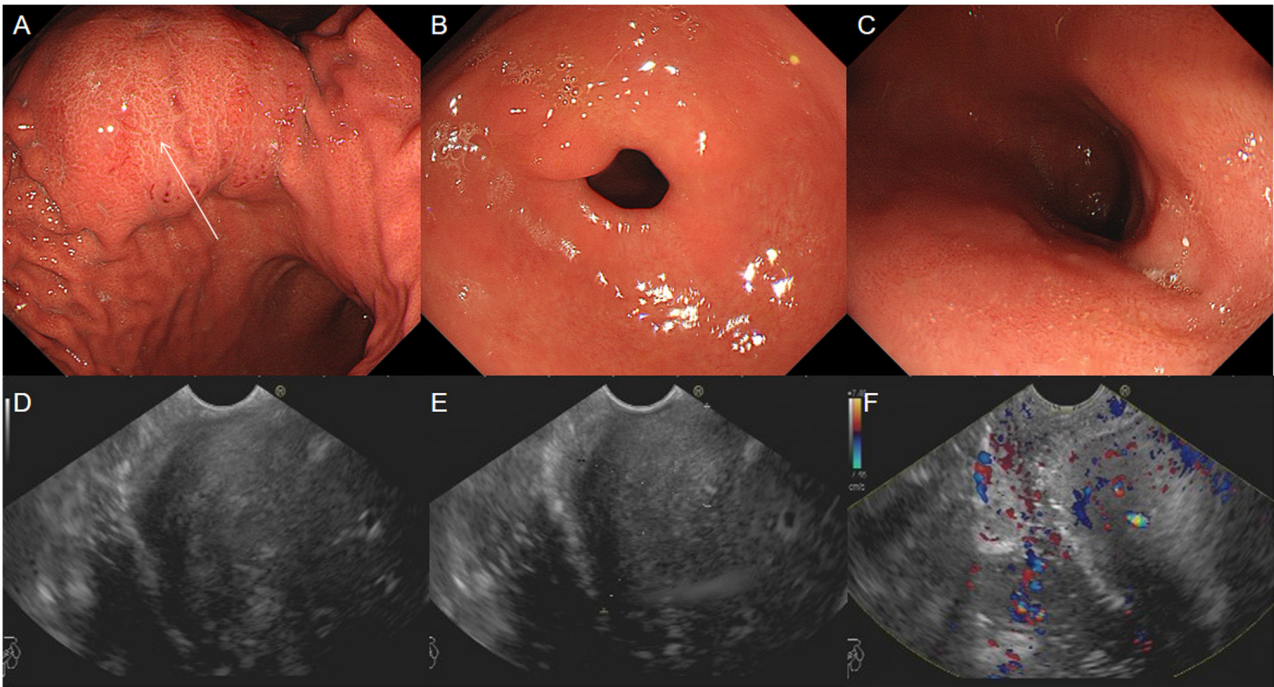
Gastroscopic findings of the gastric submucosal mass. (A) Large broad-based protruding lesion on the lesser curvature of the stomach (white arrow) with congested, smooth and intact mucosa. (B) Congested mucosa in the gastric antrum without erosion, ulceration or mass lesions. (C) Normal duodenal bulb with smooth mucosa and no abnormal protrusions or defects. (D-F) Endoscopic ultrasound performed 7 days after the above gastroscopy revealed a hypoechoic mass originating from the same gastric lesser curvature site as the lesion in (A); color Doppler imaging demonstrated visible vascular signals within the mass, indicating the presence of blood flow.
